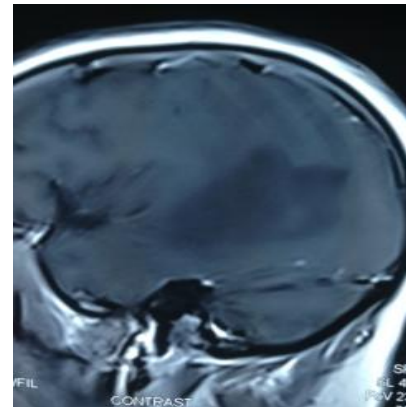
T1 image of MRI of GBM of parieto-occipital region without PE of middle aged female diagnosed by biopsy
